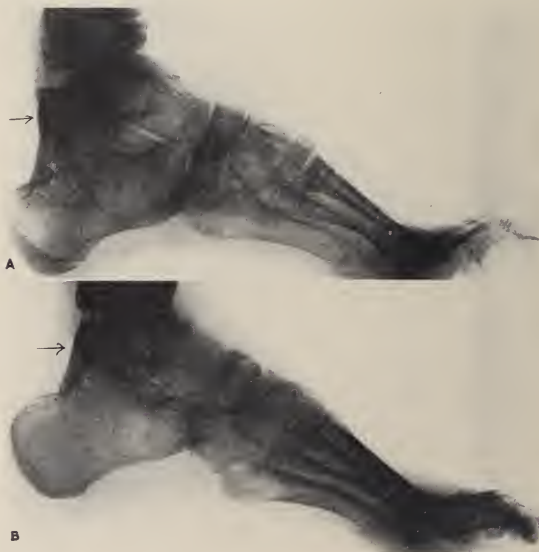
(A) X-ray appearance of bone block ten years after operation. (B) X-ray of another patient twelve years after operation.
